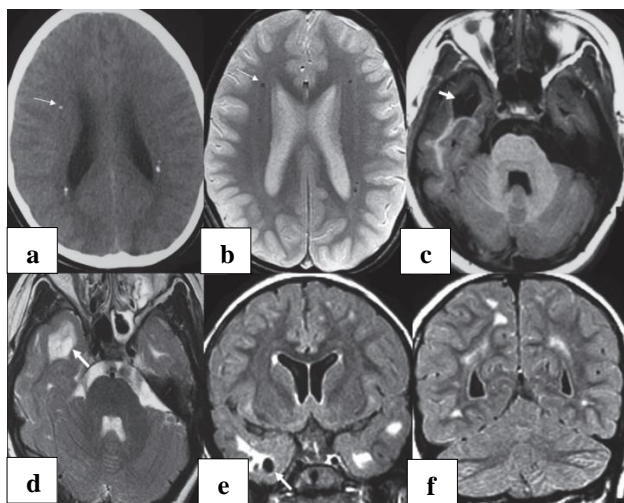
(a) On computed tomography scan; (b) gradient echo axial images, multiple small arrow-headed periventricular calcified nodules are observed; (c) cystic changes in the right temporal lobe (bold arrow) are evident on axial T1-weighted; (d) T2-weighted; (e) coronal fluid-attenuated inversion-recovery images; and (f) additionally, multiple areas of periventricular demyelination or gliosis are visible on coronal fluid-attenuated inversion-recovery images indicating possible consequences of congenital rubella infection.
